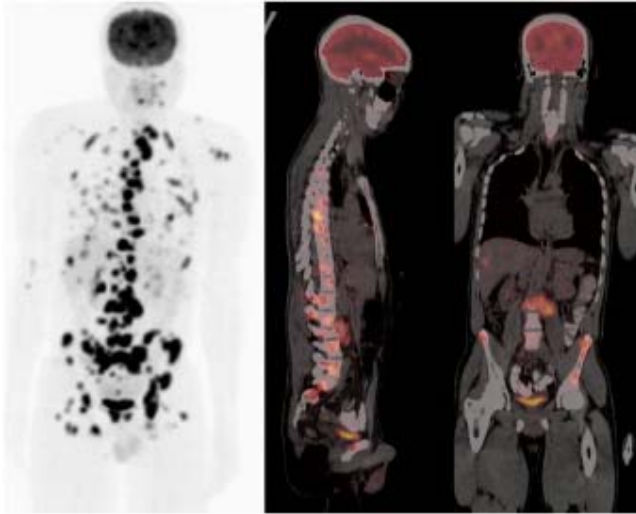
A 30-year-old male with melanoma of the head and neck region. He had surgical resection of the primary lesion with cervical dissection for removal of metastatic nodes. An FDG PET/CT scan was obtained due to complain of bone pain in the back and hips with numbness in the lower limbs. Images show liver, para-aortic lymph nodes and widespread skeletal metastases of malignant melanoma.
